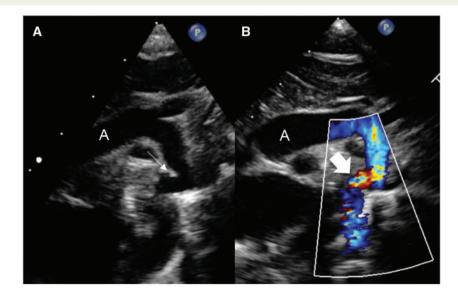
Figure I Coarctation of the aorta. (A) Two-dimensional echo and (B) colour Doppler. A, aorta; \searrow , aortic coarctation; 4, aortic coarctation with colour Doppler.
